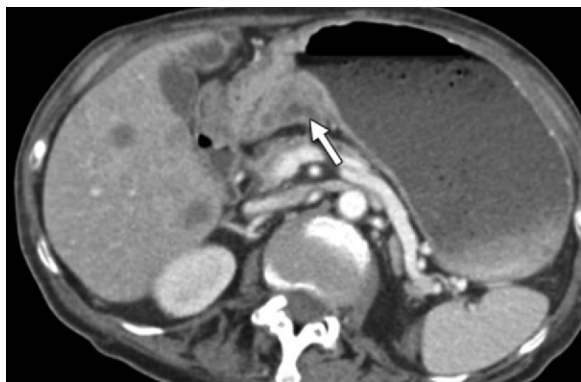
Gastric outlet obstruction in a patient with gastric adenocarcinoma. Axial CT image shows a focal heterogeneously enhancing mass (arrow) in the wall of the gastric antrum, resulting in gastric outlet obstruction. Also note hypodense liver lesions representing metastatic disease.
